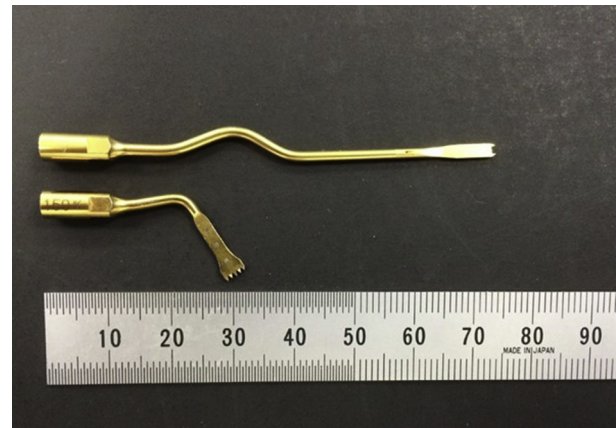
Ultrasonic bone scalpels. The horizontal, vertical, and sagittal bone cuts are performed with a short ultrasonic bone scalpel. The cortical bone and cancellous bone are separated by a long ultrasonic bone scalpel.
